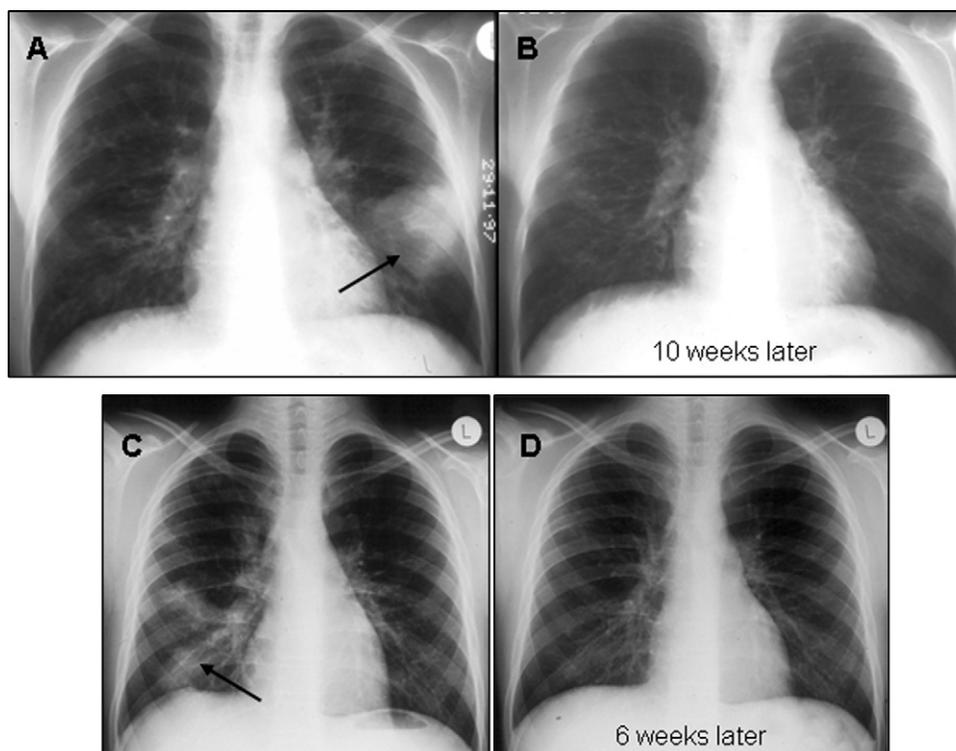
Examples of pulmonary infiltrates (arrowed) in children with cystic fibrosis and allergic bronchopulmonary aspergillosis that cleared with oral corticosteroid and oral antifungal therapy. (a, b) Child with radiographic resolution after 10 weeks. (c, d) A different child with radiographic resolution after 6 weeks.
